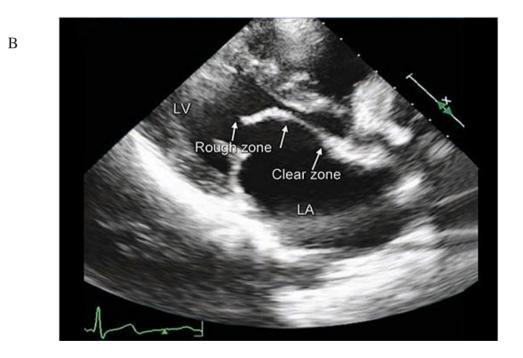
(B) 2-dimensional echocardiographic image shows the atrial zone at the base of the leaflet and the coaptation zone at the tip of the leaflet (Mohan, 2014).
